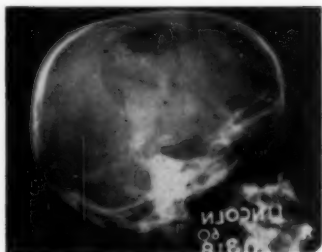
Right lateral view of skull roentgenograph of patient R. B., showing a defect produced after disposal of the depressed bone fragments. The approximate size and number of the bone chips "at-site" can also be seen spread over the defect.
